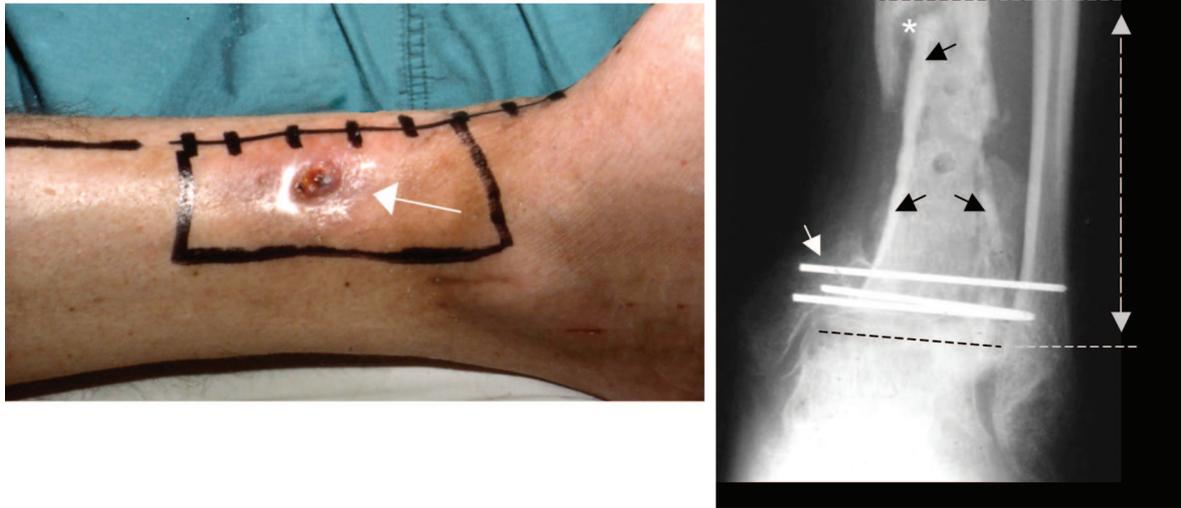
(Left) A soft-tissue deficiency (inked box) and draining fistula (white arrow) were associated with an infected nonunion of the distal tibia. (Right) This anteroposterior radiograph shows pin fixation of the tibial plafond (white arrows), sequestered cortical fragments (black arrows), a nonunion (*), and the anticipated osseous resection for infection (broken lines and arrows).
